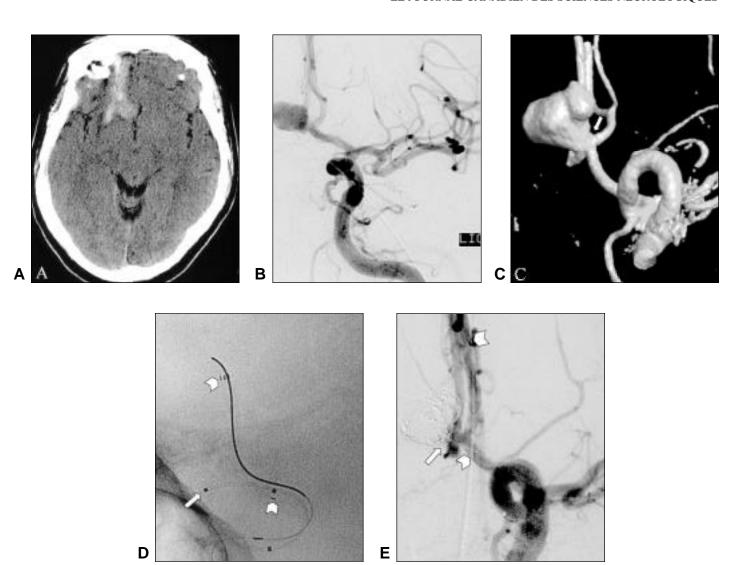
(Patient 12): (A) Unenhanced CT head shows a right frontal intra-parenchymal hemorrhage with ipsilateral subdural layering. (B) Left internal carotid angiogram revealed an aneurysm from the anterior communicating complex with both A2s filling from this side. There was a hypoplastic right first segment of the anterior cerebral artery. (C) 3-D angiographic reconstruction shows a multilobulated dome as well as a wide neck (arrow) incorporating the origin of the left second segment of the anterior cerebral artery. (D) Parallel technique was chosen. The long arrow indicates the tip of the microcatheter within the aneurysm sac. The short arrows indicate the markers of the microstent within the first and second segments of the left anterior cerebral artery. (E) Complete packing of the aneurysm was achieved at the end of the procedure (Class 1 result). The long arrow shows the tip of the microcatheter at the neck of the aneurysm at the end of coiling. The short arrows indicate the markers of the microstent.
